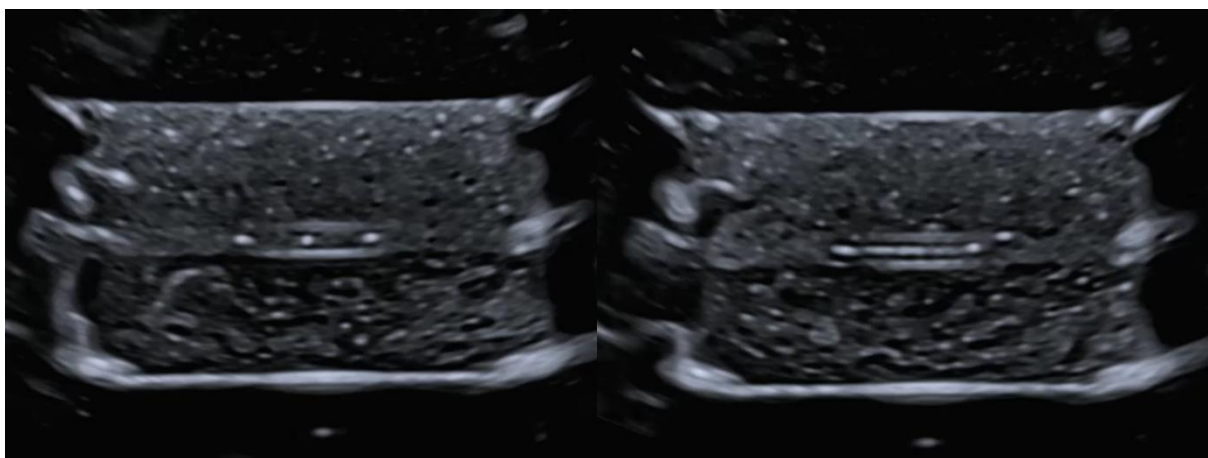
Ultrasound image of the first arrangement of wires. Left, the individual wires can be seen as 3 bright dots when the imaging plane intersects them. Right, the perpendicular wire shows as a bright line as it intersects the imaging plane.
